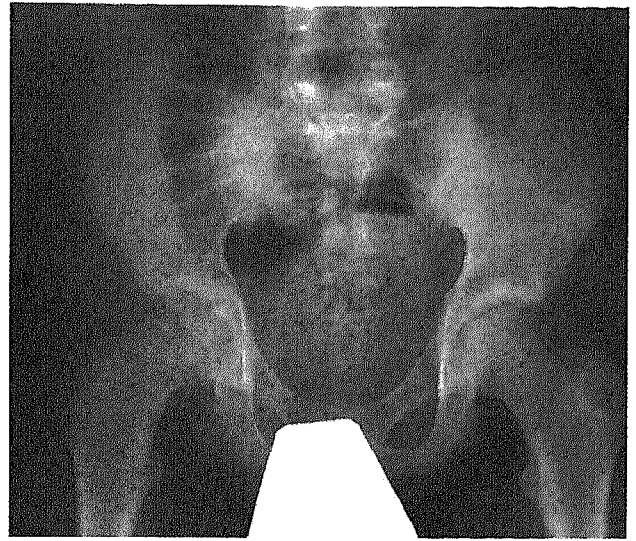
An anterior-posterior pelvic radiograph of a 13-year-old boy with slipped capital femoral epiphysis of the right hip. The hip on the left was asymptomatic at the time the radiograph was taken, the peak shear stress in its epiphyseal growth plate equals 0.85 MPa. The geometrical features of the left—unslipped—hip include more vertical oriented epiphysis, wider femoral neck for the given head radius, and wider crista iliaca in comparison to the normal hips in Figure 2.
